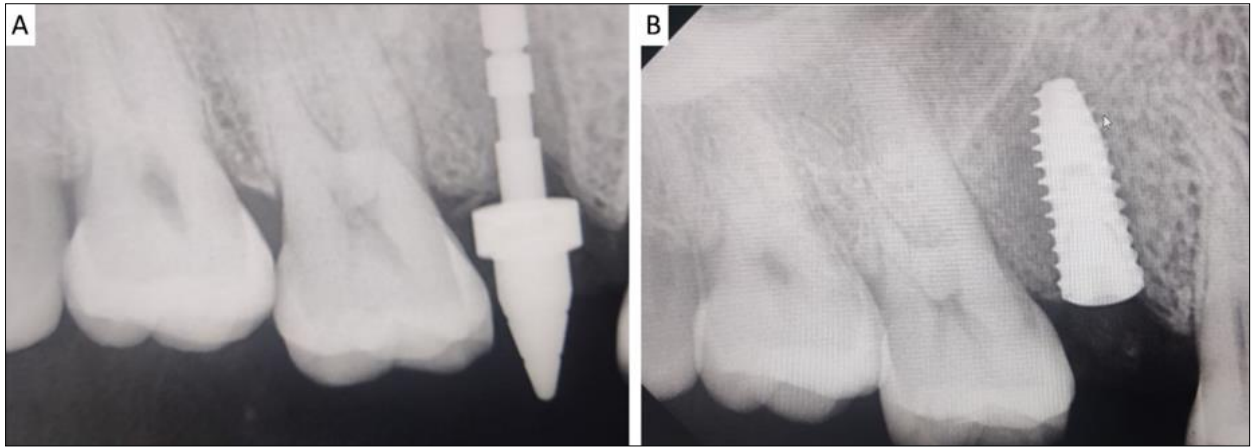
Intra-oral periapical radiographs showing A) parallelism pin placement and B) implant placement
